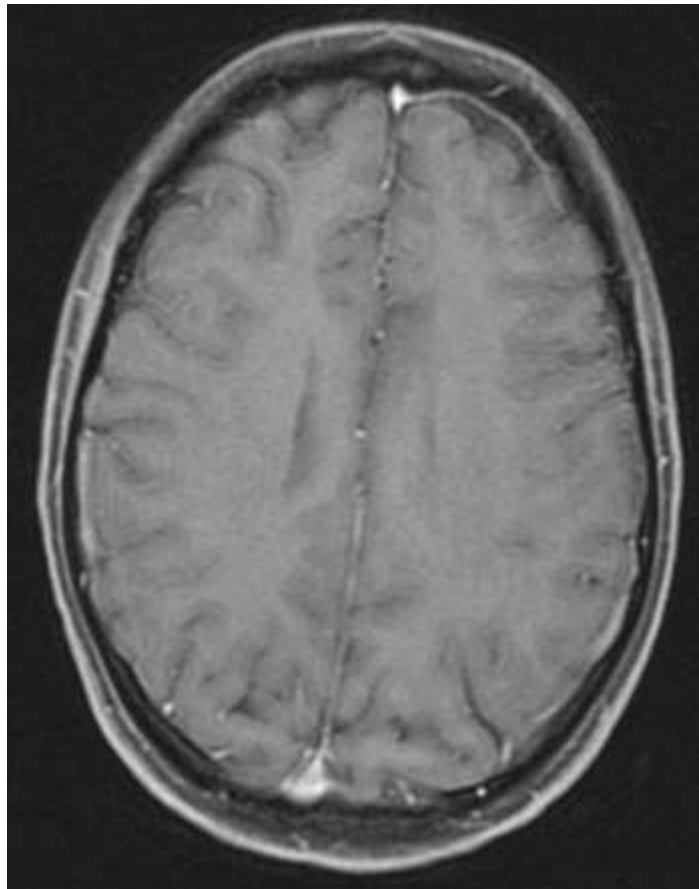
MRI corresponding to level A in Fig. 24.5B.
